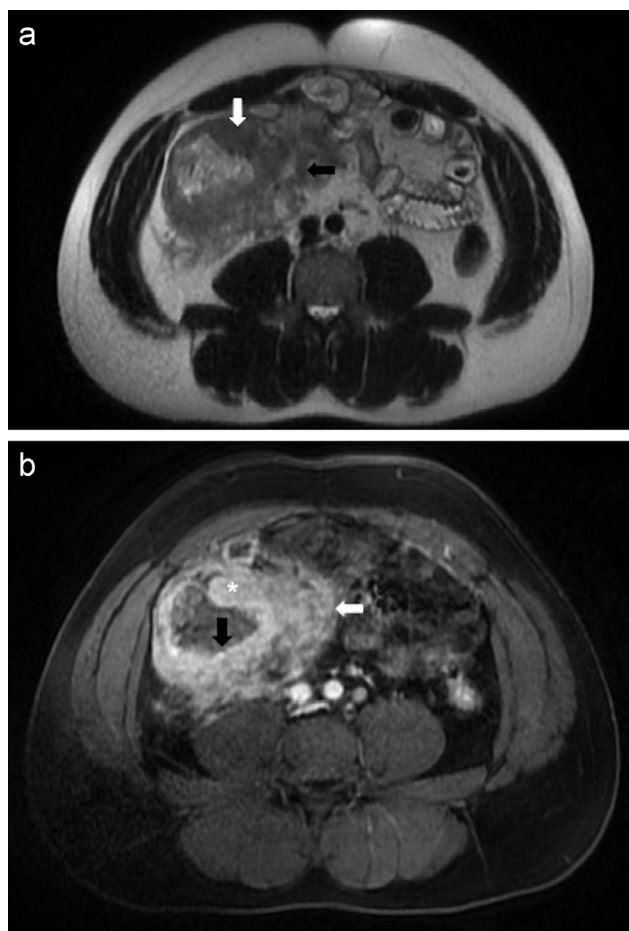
Initial MR study. (a) Axial T2-weighted half-Fourier single-shot fast spin-echo (SSFSE) 1.5 T MR image (repetition time ms/echo time ms, 1009/91.2; 6 mm section thickness), showing the thickening of the wall of the cecum (white arrow) and significant stranding of the pericolic fat (black arrow). (b) Axial fat-suppressed T1-weighted 3D-GRE (gradient echo) 1.5 T MR images (repetition time ms/echo time ms 4.148/1.98; 5.4 mm section thickness) after administration of intravenous contrast material at the arterial phase. Note the thickening of the wall of the cecum (asterisk), with transmural enhancement. There are areas of mucosal irregularity and ulceration (black arrow) and significant stranding of the pericolic fat (white arrow), which also shows enhancement, due to abundant pericolic inflammation.
